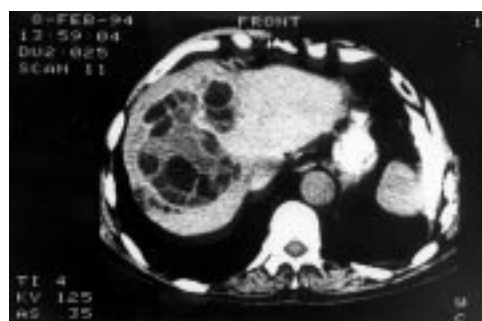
Figure CT scan of the liver
